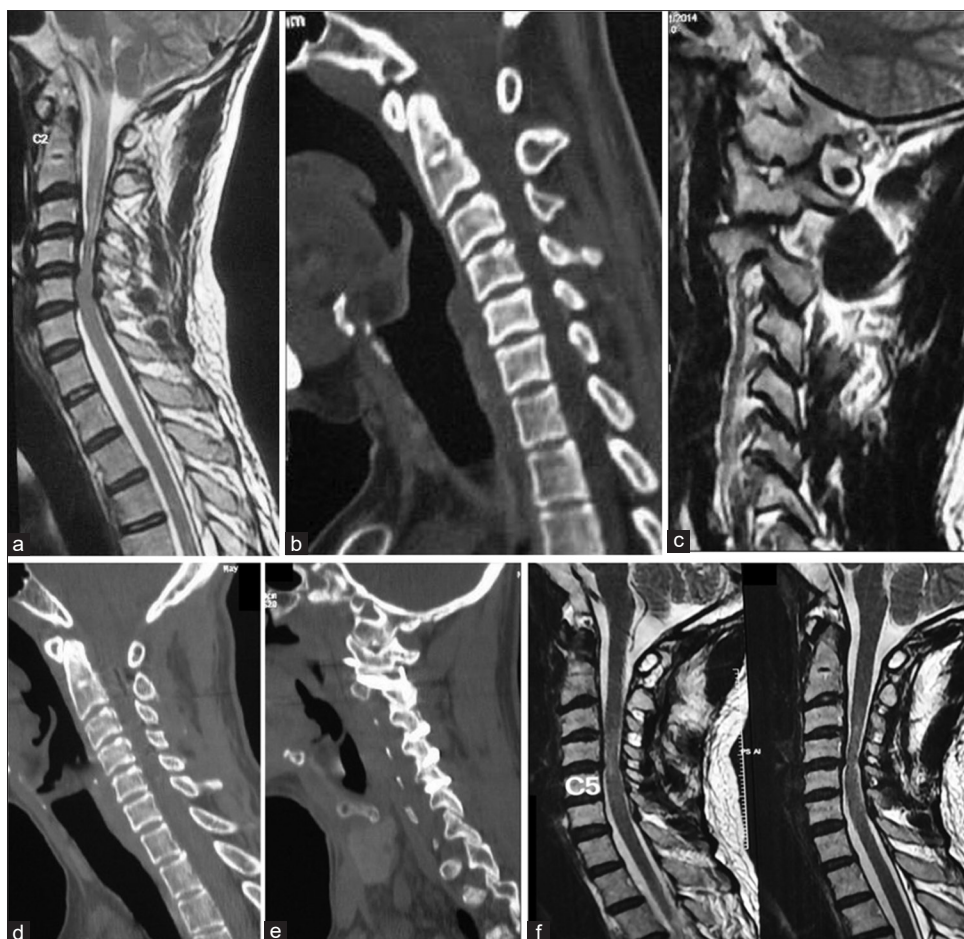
Images of a 40-year-old male. (a) T2-weighted magnetic resonance imaging showing evidence of multilevel spinal cord compression by osteophytes and buckled ligamentum flavum. (b) Computed tomography scan showing no evidence of atlantoaxial instability. (c) Magnetic resonance imaging cut passing through the facets showing type 2 atlantoaxial facetal instability. (d) Postoperative computed tomography scan. No bone decompression is seen. (e) Computed tomography scan cut passing through the facets showing C1-2, 2-3, 3-4, 4-5, and 5-6 fixation. (f) Postoperative magnetic resonance imaging 6 months after the surgery shows reduction in the extent of neural compression by the osteophytes and bulging ligamentum flavum
